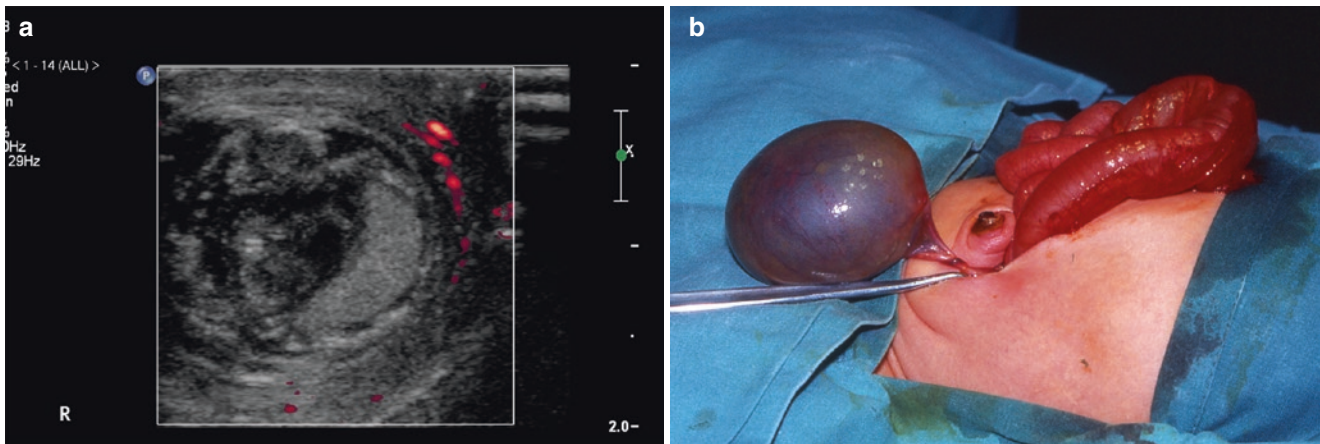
(a) Antenatal torsion of the ovary. This scan shows disruption of the ovarian tissue indicating necrosis and the colour Doppler shows poor flow. (b) Ovarian torsion in a neonate. This is a preoperative view of the fallopian tube and a cyst probably due to an antenatal torsion
